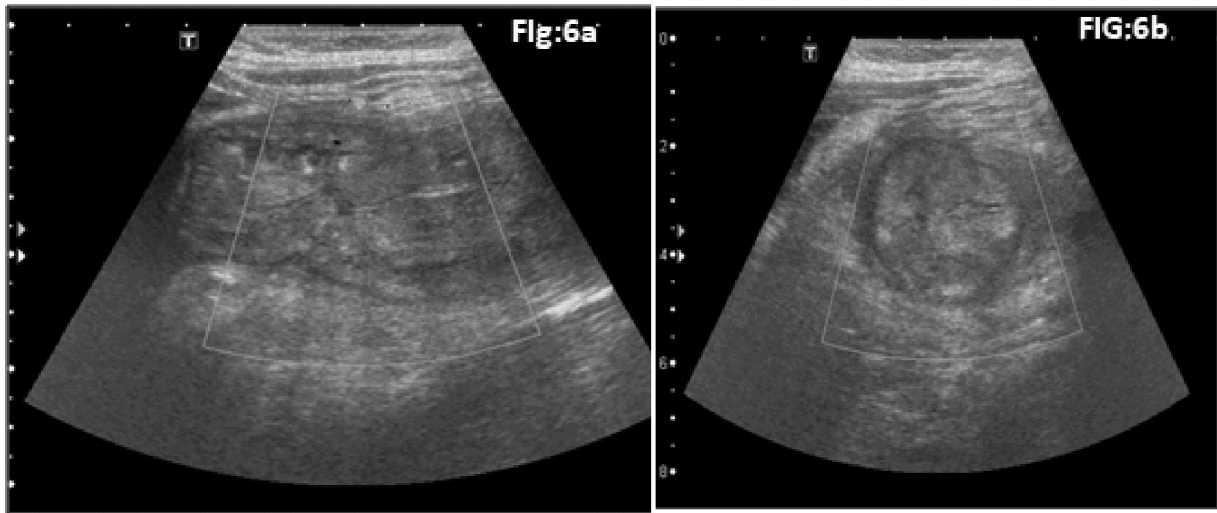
A, B : Sonography: focal bowel wall thickening
